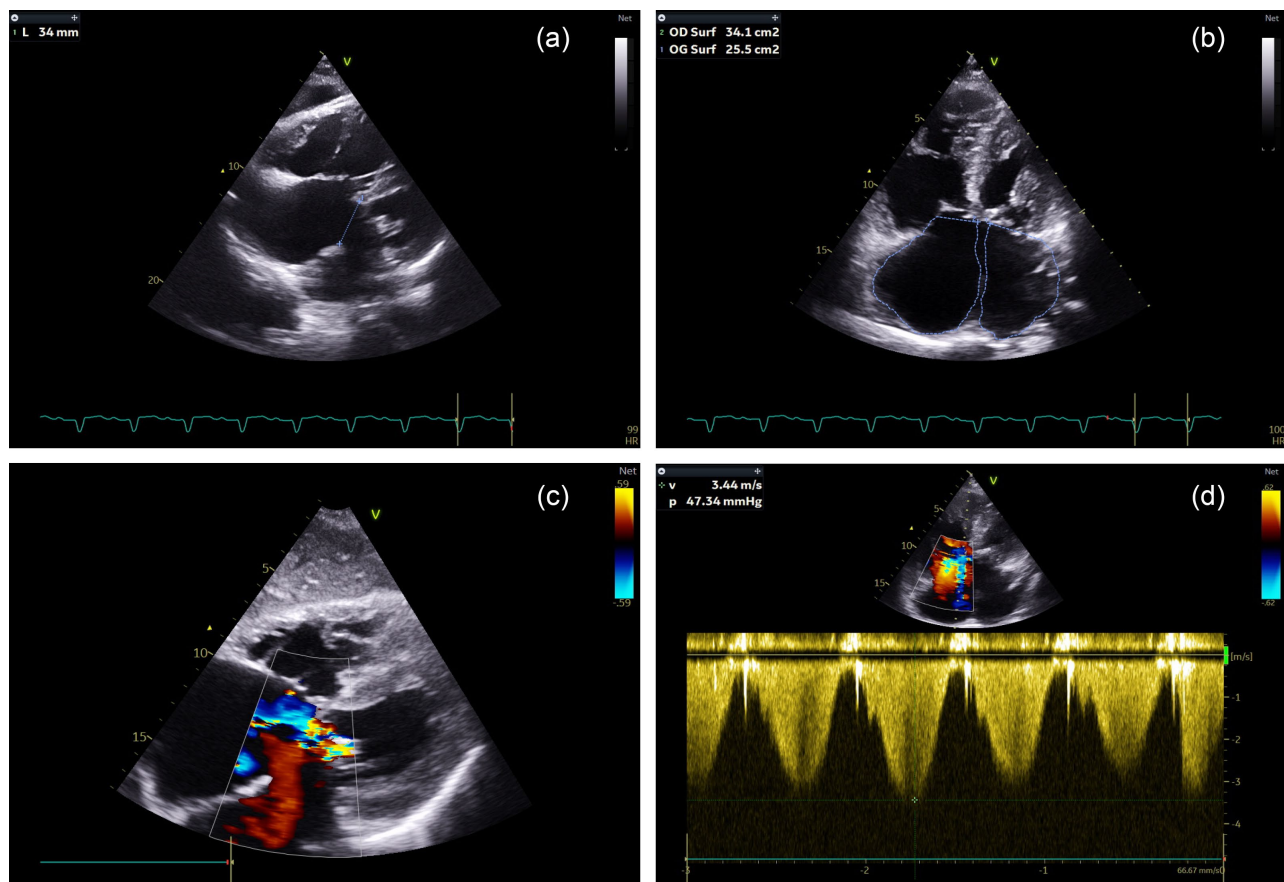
Comprehensive echocardiographic findings. (a) Apical four-chamber view demonstrating large ostium primum atrial septal defect measuring 34 mm (white arrow), common atrioventricular junction at the crux of the heart, and significant right atrial and right ventricular dilatation; (b) Quantification of cardiac chambers showing marked right-sided enlargement (right atrium surface 34.1 cm², left atrium 25.5 cm²), confirming chronic volume overload from left-to-right shunting; (c) Color Doppler imaging in apical four-chamber view revealing significant left-to-right shunting through the ostium primum defect (blue jet) and severe regurgitation of both left and right components of the common atrioventricular valve (multicolor turbulent jets); (d) Continuous-wave Doppler interrogation of tricuspid regurgitation jet demonstrating peak velocity of 3.44 m/s, corresponding to estimated right ventricular to right atrial pressure gradient of 47 mmHg. Assuming right atrial pressure of 10 mmHg (elevated due to right heart failure), estimated systolic pulmonary artery pressure is 57 mmHg, confirming severe pulmonary arterial hypertension. Abbreviations: CIA = communication interatriale (atrial septal defect); OD = oreillette droite (right atrium); OG = oreillette gauche (left atrium); PASP = pulmonary artery systolic pressure.
